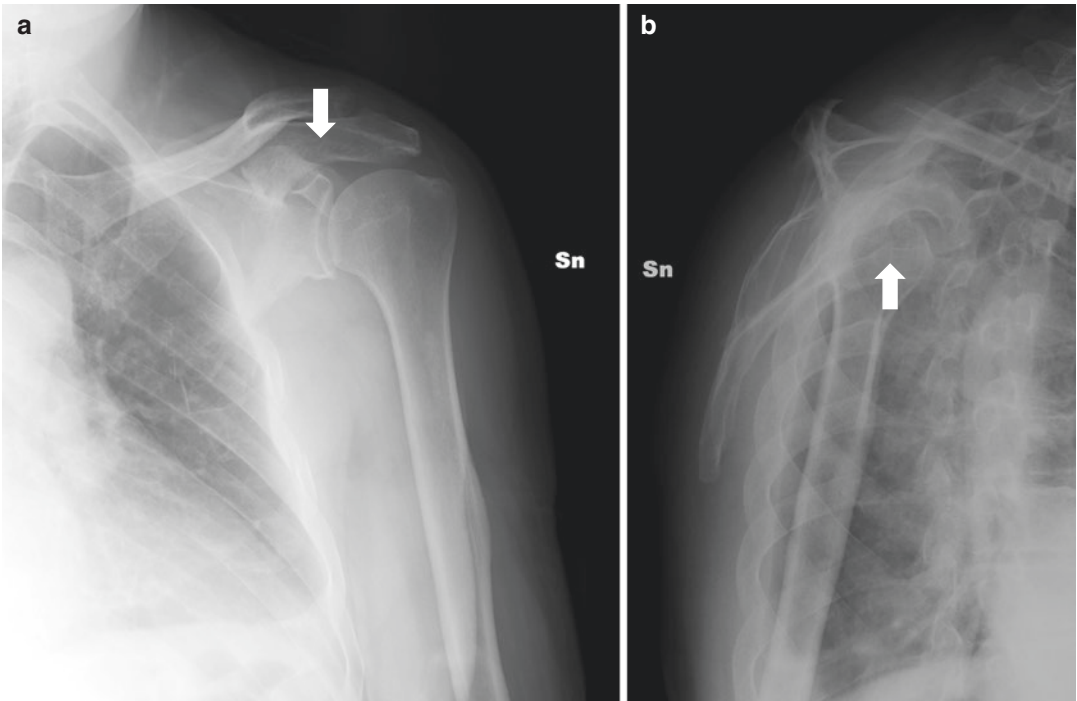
Anterior-posterior (a) and Y (b) X-ray shoulder projections of a 64-year-old man after thoracic blunt trauma showing multiple fractures of the left scapula with fragments displacement (arrows)
